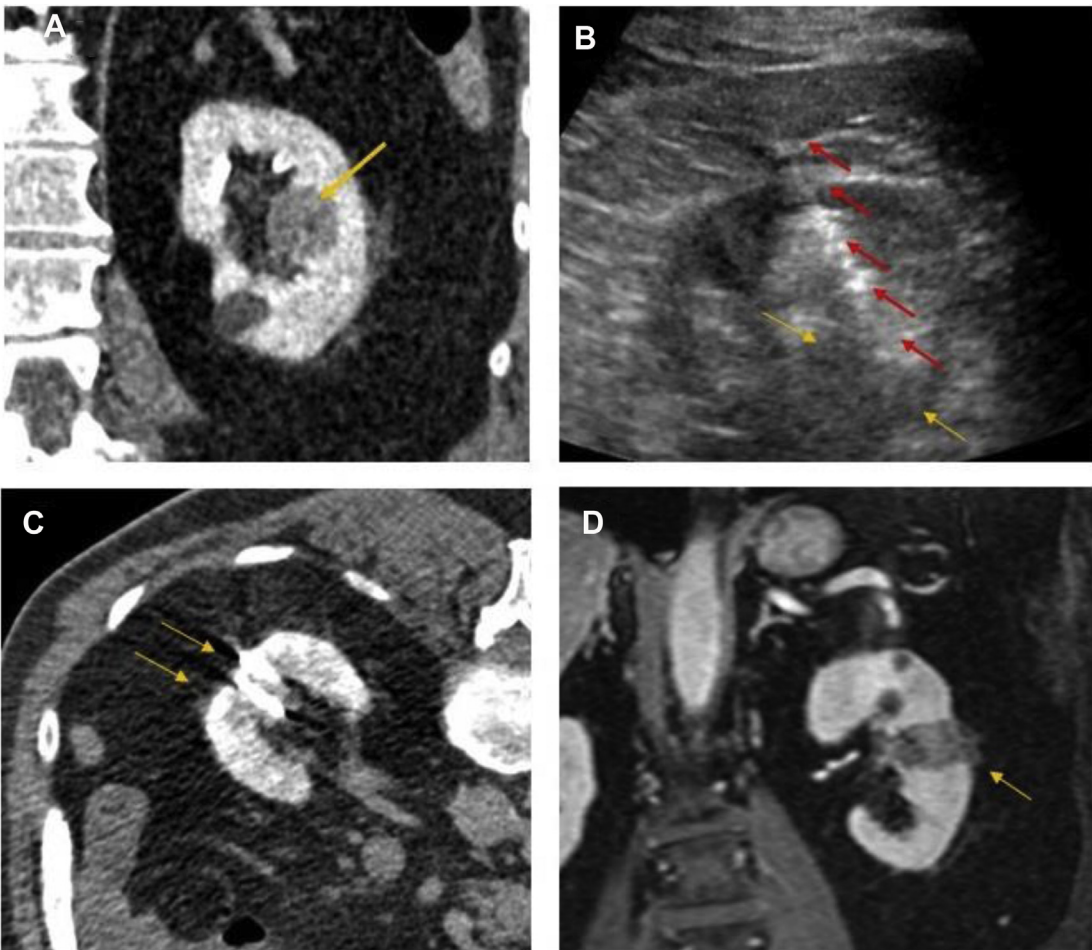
A 62-year-old man with 4-cm clear cell RCC. Two microwave probes (red arrows) placed into the tumor (yellow arrows) with multidetector CT (corticomedullary, nephrographic, and excretory phases) (A–C). After the procedure, MR confirmation on coronal view shows the successful ablation with no residual tissue (D).
